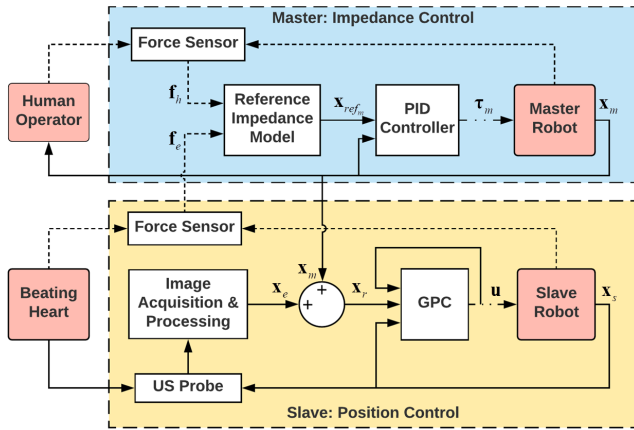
The telerobotic beating-heart surgical system with ultrasound image guidance and force feedback. The solid lines indicate the position transfer paths. The dashed lines indicate the force transfer paths. The dash-dotted lines are control signals.
